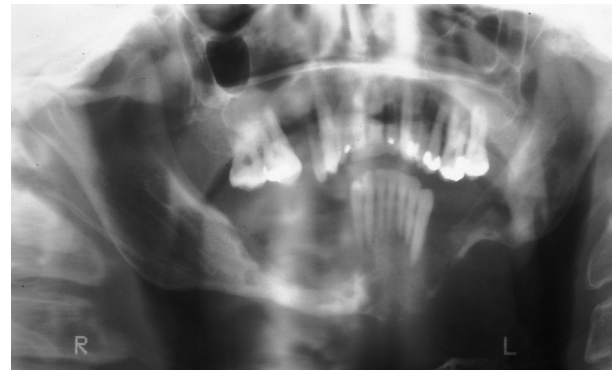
Panoramic radiograph of an eosinophilic granuloma of the mandible. Note the destructive process of the mandible, with “teeth floating in air.”
